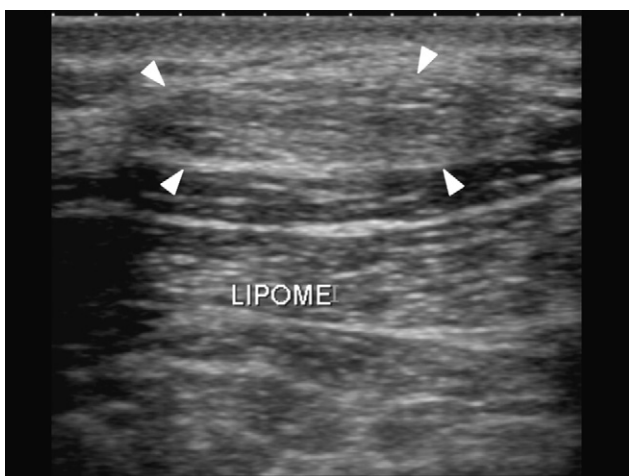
Sonography of the upper part of the back: Superficial, solid, ovoid formation that is non-homogenous, avascular on Doppler imaging, and contains linear echogenic zones. This is an epidermoid cyst.
